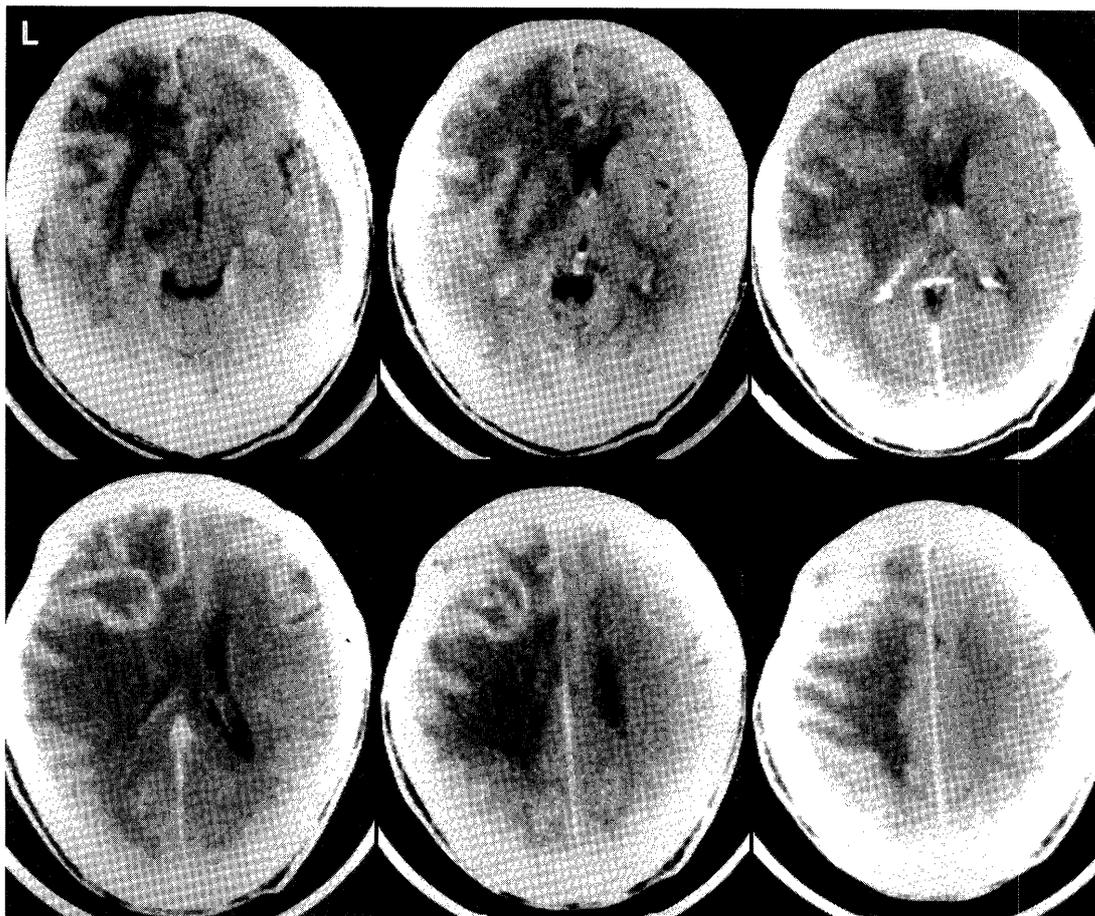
Postcontrast CT scan obtained 2 years after radiation therapy, showing a heterogeneous mass with ring enhancement surrounded by a low-density lesion in the left frontal region.
